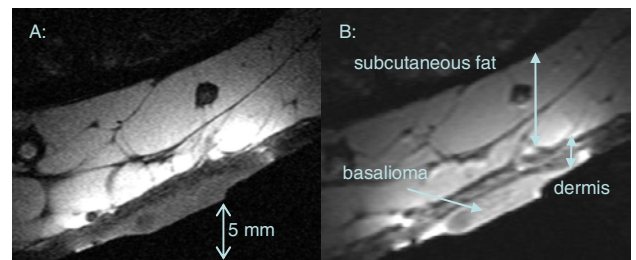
In vivo MRI of a basaloma over the tibia using the surface coil. T1-weighted 2D spin-echo:
